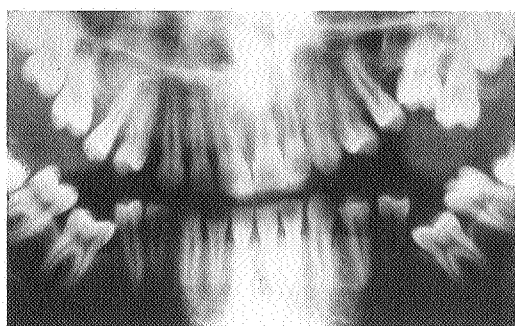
Orthopantomograph X-ray at the age of 14 years.
